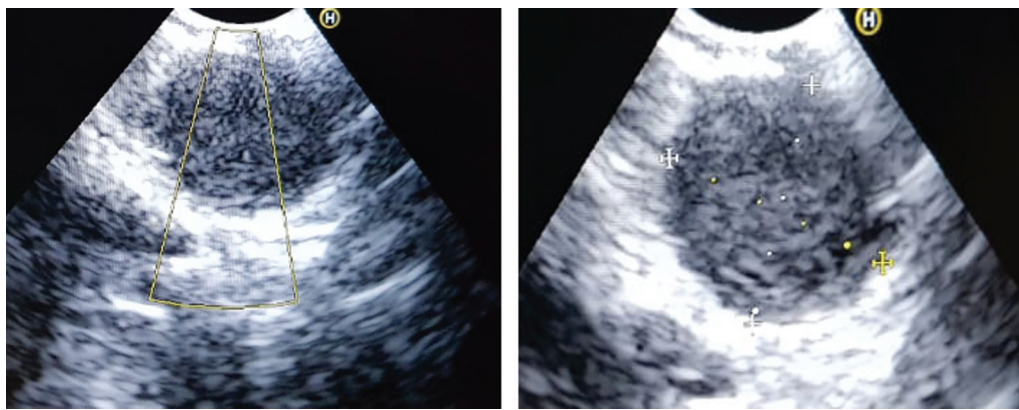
Endobronchial ultrasound (EBUS) showing an example of a mediastinal node with features predictive of malignancy: rounded shape, absence of well-defined vascular hilum, and heterogeneous/hypoechoic echotexture.
